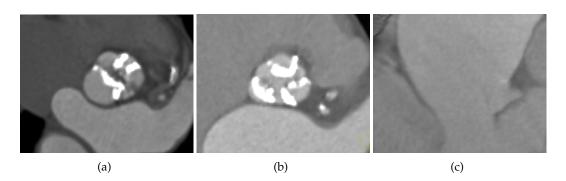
Examples of the aortic valve in CT with (a) bicuspid anatomy, (b) stenotic and heavy calcified aortic valve and (c) dilated aortic valve.
